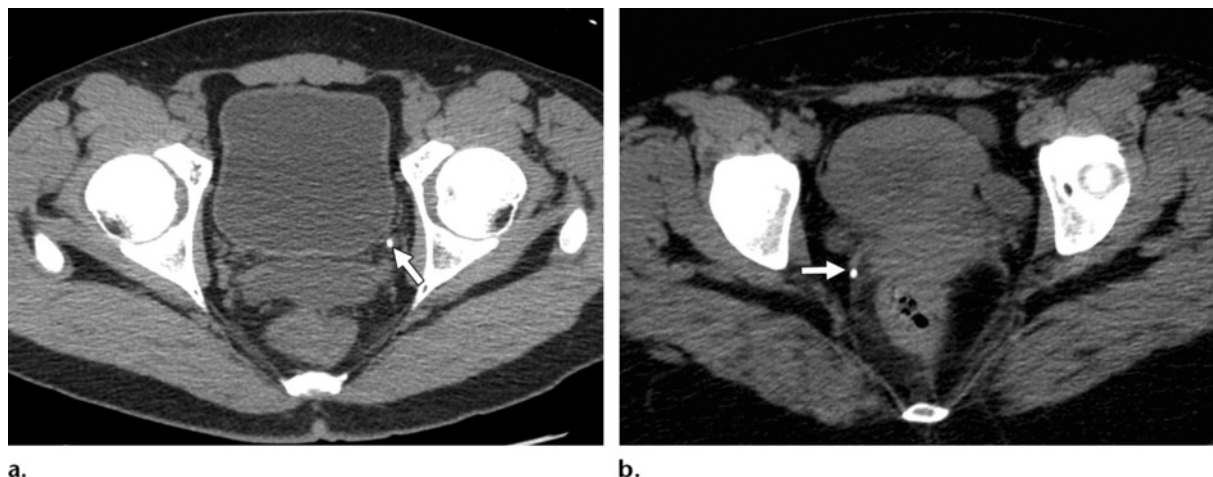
(a) Soft-tissue rim sign. Axial unenhanced multidetector CT scan obtained in a 44-year-old man with acute left pelvic pain shows a distal ureteral calculus (arrow) with surrounding soft-tissue attenuation that represents edema of the ureteral wall. (b) Comet tail sign. Axial unenhanced multidetector CT scan obtained in a 49-year-old woman shows the comet tail sign, created by an eccentric tapering soft-tissue area adjacent to a calcification (arrow).
